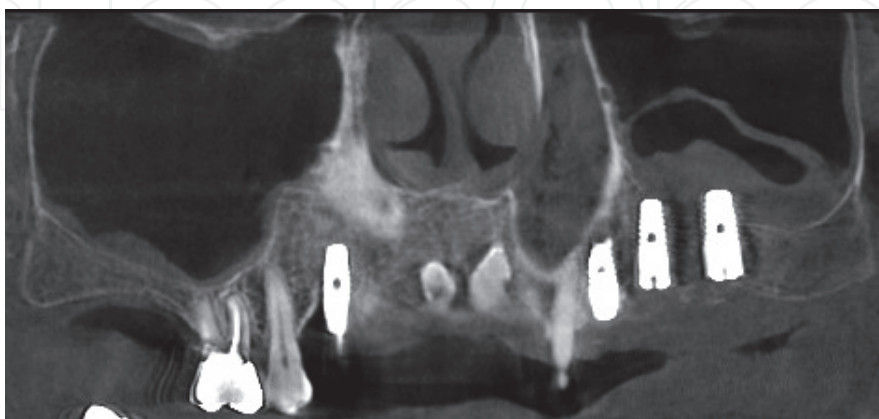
Postoperative cone beam CT scans showing membrane elevation and implant placement in the left sinus.
